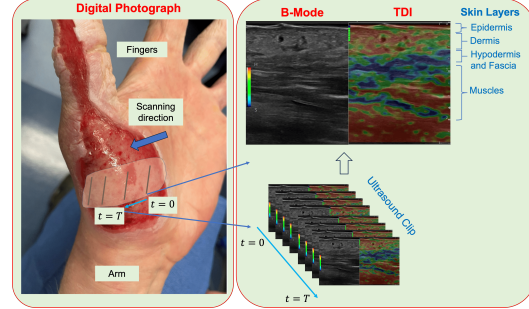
Representative samples from the dataset. Left: digital photographs of burn wounds. Right: paired ultrasound images, with B-Mode showing tissue structure and TDI visualizing perfusion.
